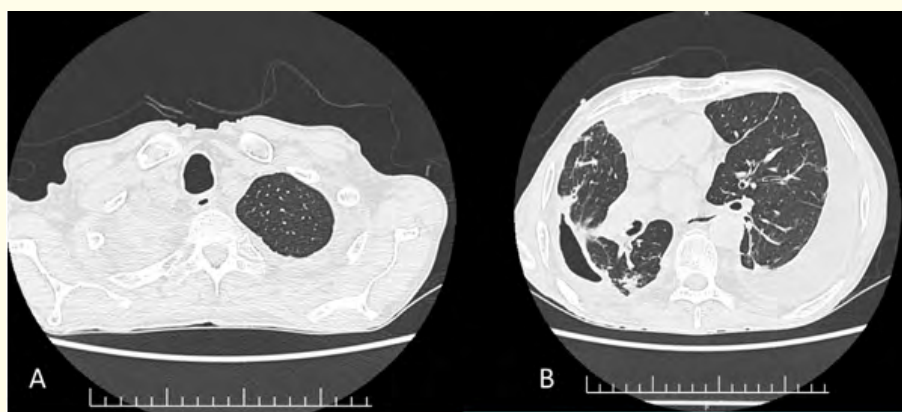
HRCT Thorax showing pleural effusion, pleural fibrosis, parenchymal fibrosis and nonhomogeneous parenchymal shadows.
